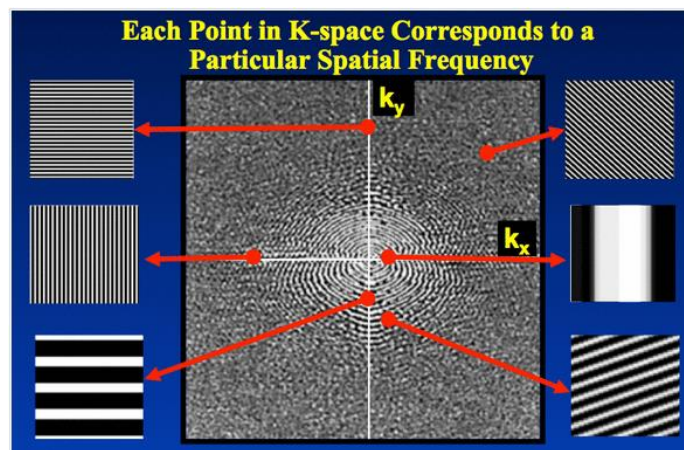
The k_x coordinates represent the frequency components along the x-direction of the image. Inversely, the K_y coordinates are related to the frequency components along the y-direction of the image. MR images have frequency components in all directions. A bright point in the k -space shows
